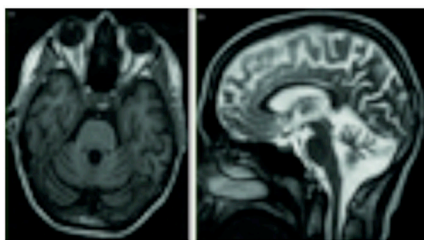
Cerebellar atrophy in individual MR 3-3 with an p.Arg420His mutation. A) T1-weighted axial image of posterior fossa. B) T2-weighted midsagittal image, note lack of brainstem atrophy.
